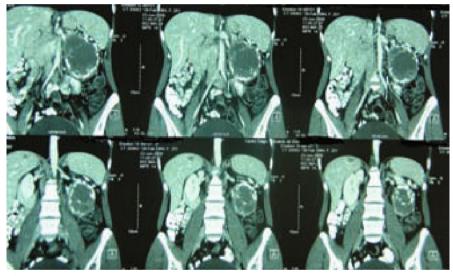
Coronal CT of a solid pseudopapillary carcinoma of the pancreas in a 26-year-old female patient. A hepatic metastatic lesion is visible in segment VIII
